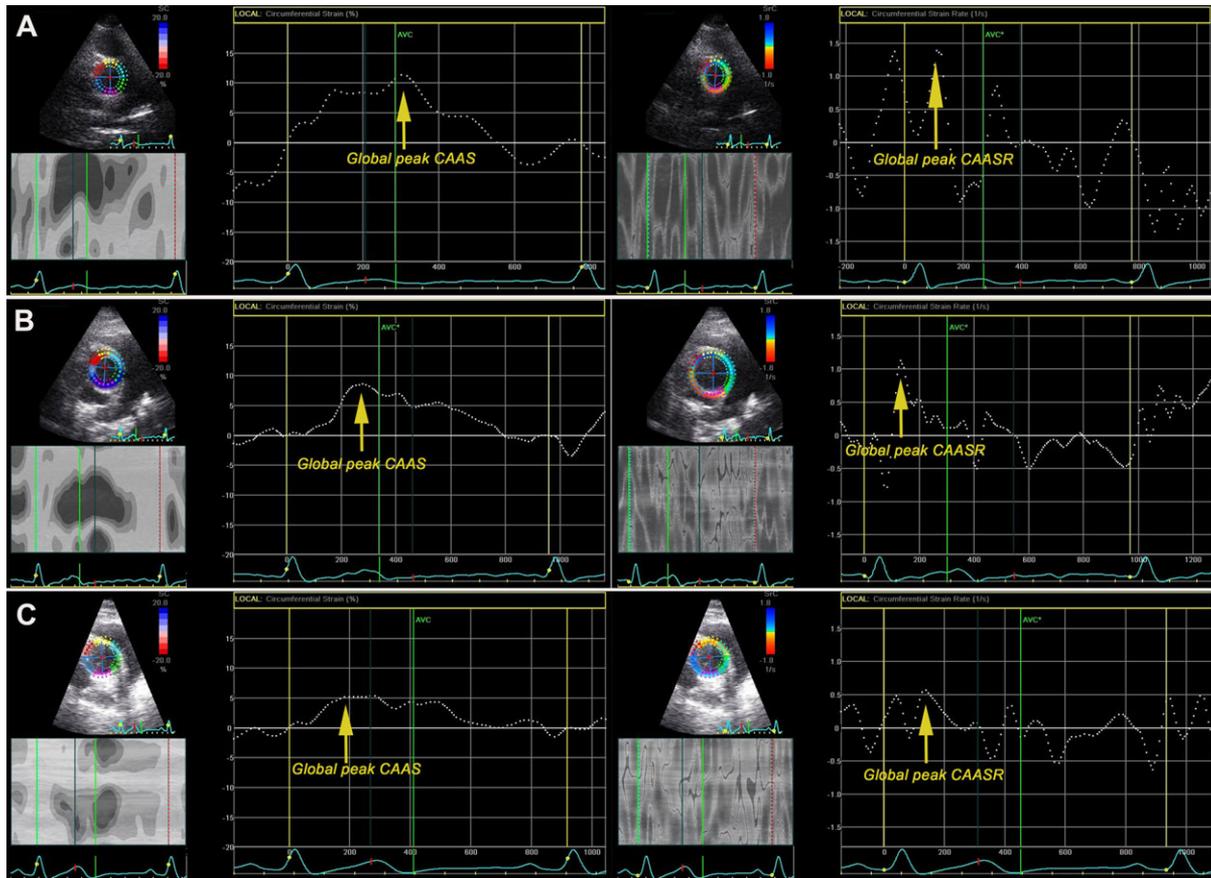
Assessment of ascending aorta mechanics via 2DST echocardiography generated from short-axis view of aorta, 2–3 cm above aortic valve: quantitative curves representing all regions in a control subject (A), in a patient with isolated AR (B) or isolated AS (C). Peaks of CAAS (in proximity to aortic valvular closure) and CAASR (first peak after ventricular systole) both assume positive values due to expansion of vessel wall.
